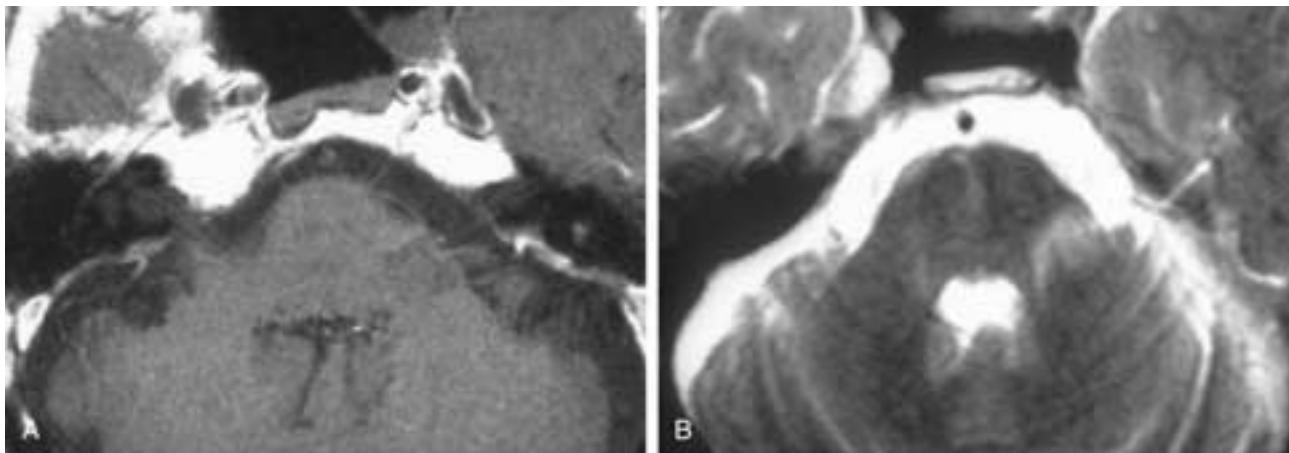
AICA infarct. A, T1-weighted image. A hypointense, nonexpansile pontocerebellar lesion is seen in the territory of the AICA. B, T2-weighted image. The infarct is seen as a hyperintense lesion without mass effect.
